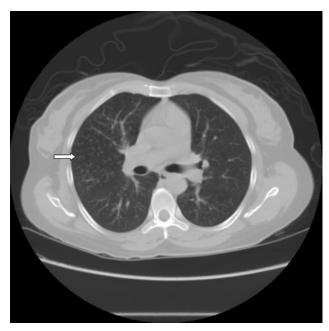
High-resolution computed tomography image shows multiple centrilobular nodules, many of which connect to branching linear structures (arrow): tree-in-bud pattern.
